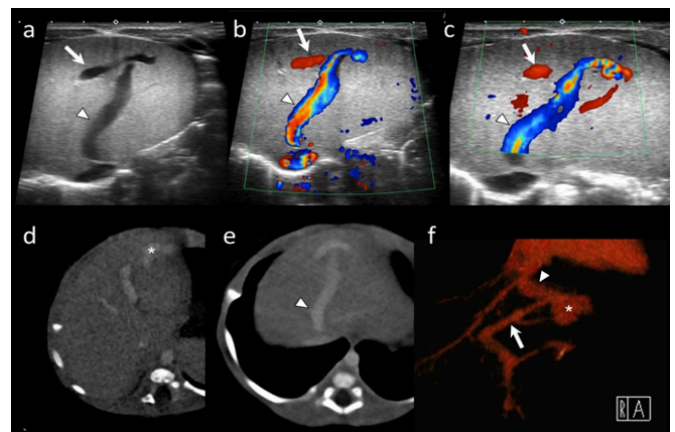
One-month-old female patient. B-mode US (a), Doppler US (b, c), axial CTA (d, e), and volume rendering technique (VRT) image (f) of aneurysmatic (\*) CPSS between left portal vein (arrow) and middle hepatic vein (arrowhead). Note that the asymmetric dilatation of the middle hepatic vein (arrowhead) due to diverted blood flow from the portal system
